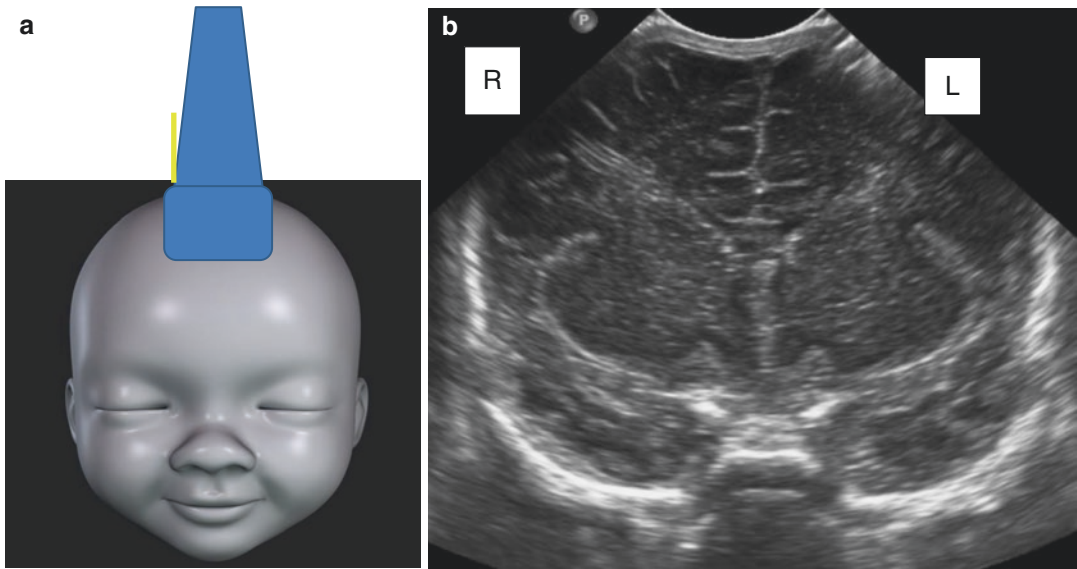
(a) Adequately fitting linear ultrasound probe, positioned onto the anterior fontanelle. The yellow mark indicates the marker on the probe pointing to the right of the patient. (b) Coronal ultrasound image using a curvilinear
